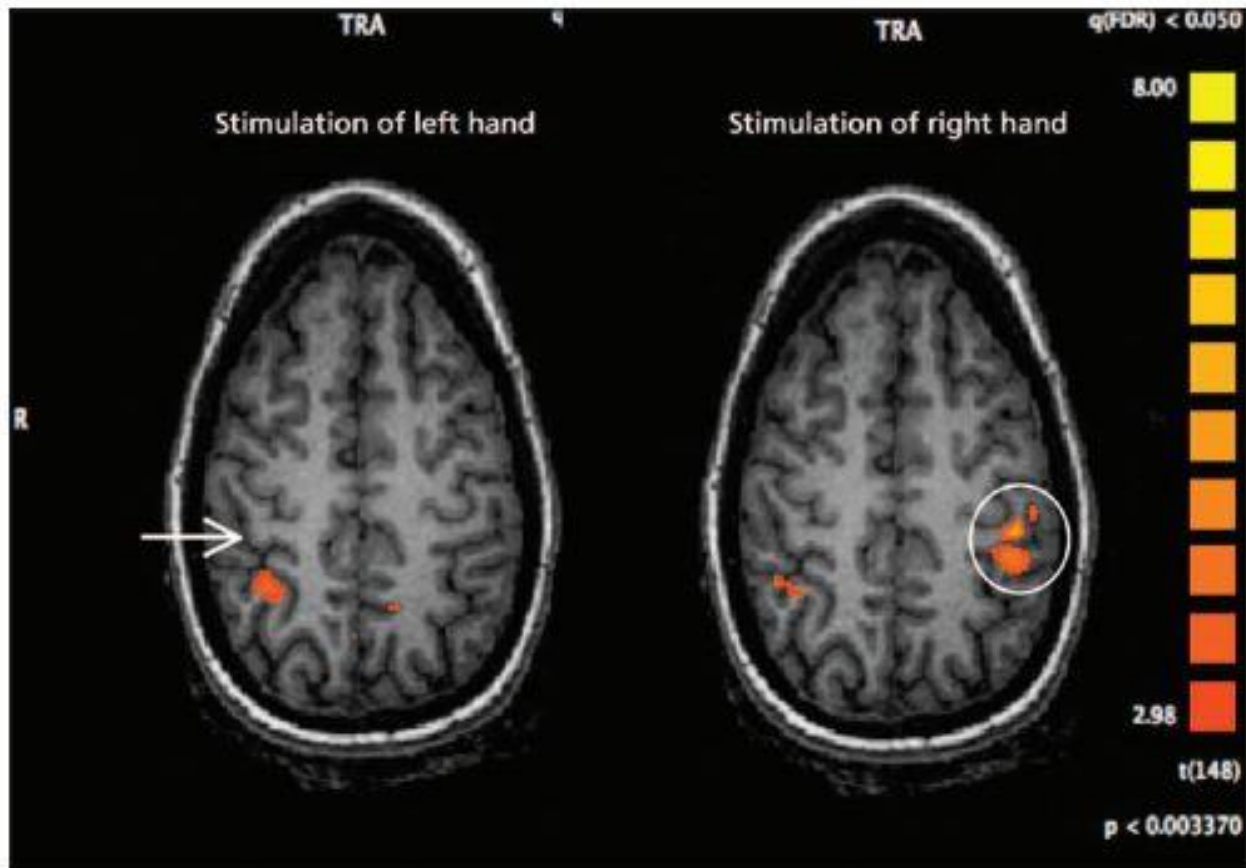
Functional magnetic resonance image showing somatosensory activity evoked by stimulation in a patient with sensory conversion disorder affecting the left hand. When the patient's left hand was stimulated, no activity was seen in the primary somatosensory cortex (arrow). However, increased activity was seen in this area of the brain when the patient's right hand was stimulated (circle).
